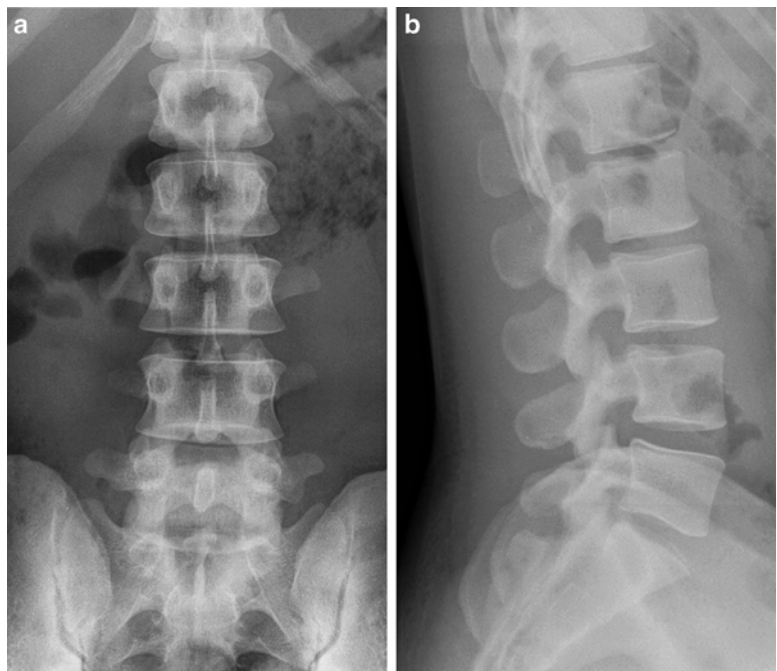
Normal frontal (a) and lateral (b) lumbar spine radiographs
